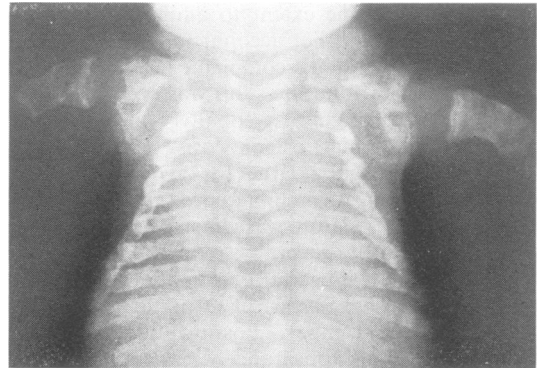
Lethal perinatal OI. X-ray of the chest showing beaded or 'rosary' appearance.
